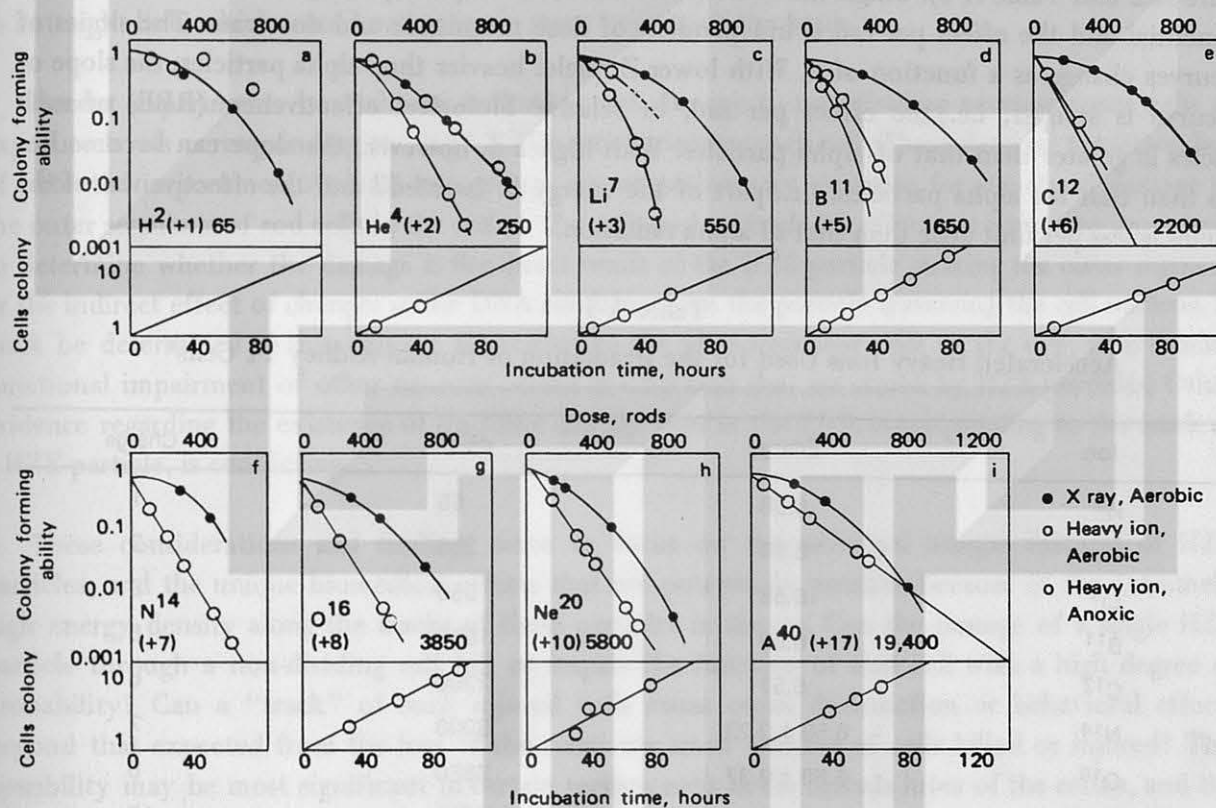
Figure A-2. Response of T1 cells to irradiation with heavy ions of equal velocity. The curves, left to right, top to bottom, are for the ions (descending order). The abscissa legend, top, is the dose in rad. The solid circles are for X-ray controls. (From Todd, and similar to that shown in *Radiation Research, Space Radiation Biology*, Supplement #7, September 7, 1967, p. 196).
